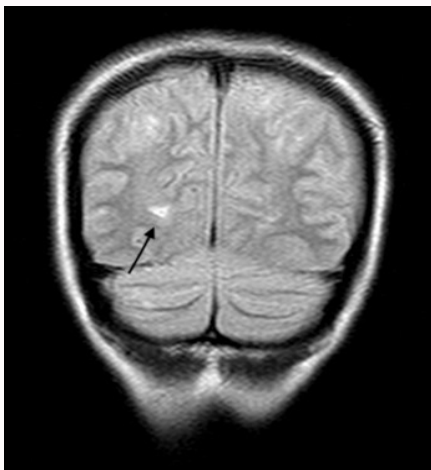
Cranial MRI imaging showing hyperintense lesions in the occipital subcortical white matter and in the cerebellar hemispheres that could be suggestive of reversible posterior leukoencephalopathy.
